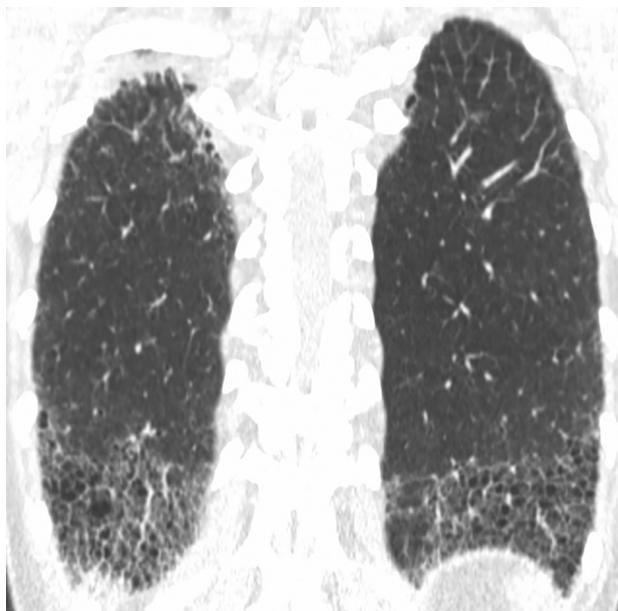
A 51-year-old male with RA and UIP. Coronal reformatted HRCT image shows basal predominant reticulation and honeycombing. The relatively horizontal interface between abnormal and normal lungs has been described as the “straight-edge sign.” RA, rheumatoid arthritis; UIP, usual interstitial pneumonia.
